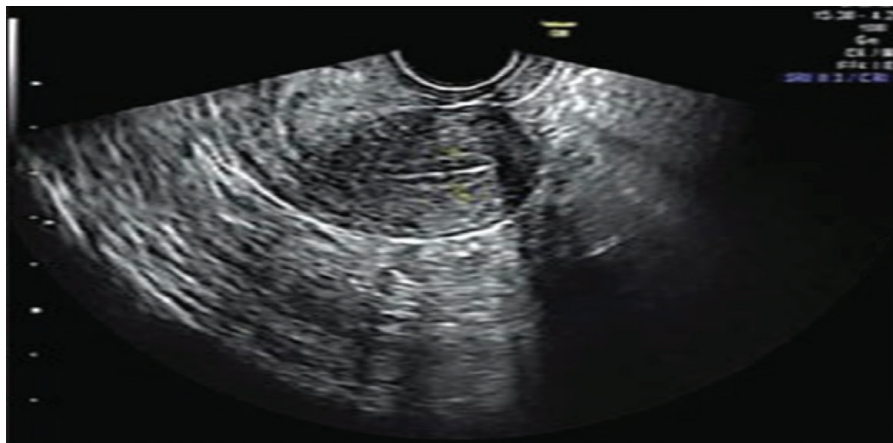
An ultrasound image demonstrating a smooth and homogeneous endometrial pattern with a well-defined triple-line sign (echogenicity pattern) (a woman 29 years old; the 3rd day of the menstrual cycle)
